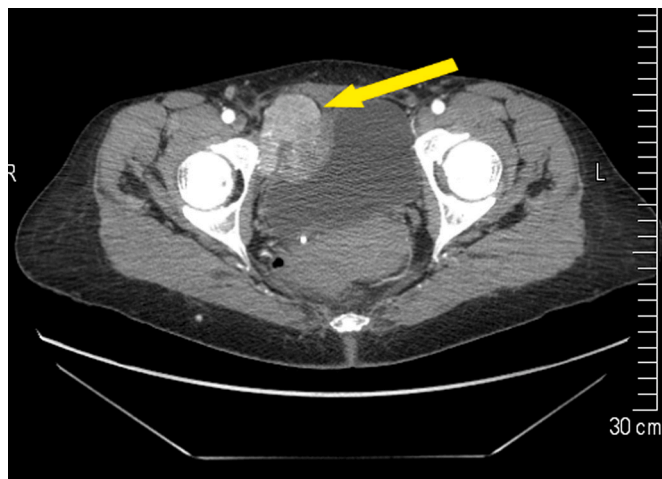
CT scan showing a heterogeneous mass in the right iliac fossa.
